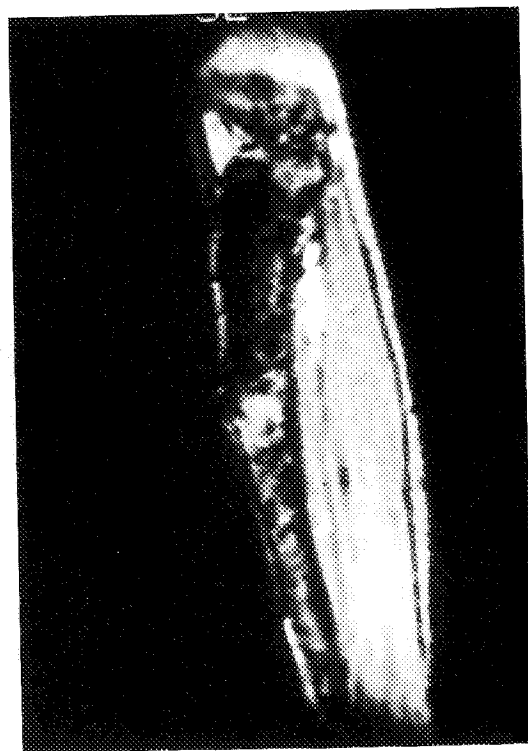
Magnetic resonance image showing an area of increased signal, indicating fibrous dysplasia in the midtibial region.
